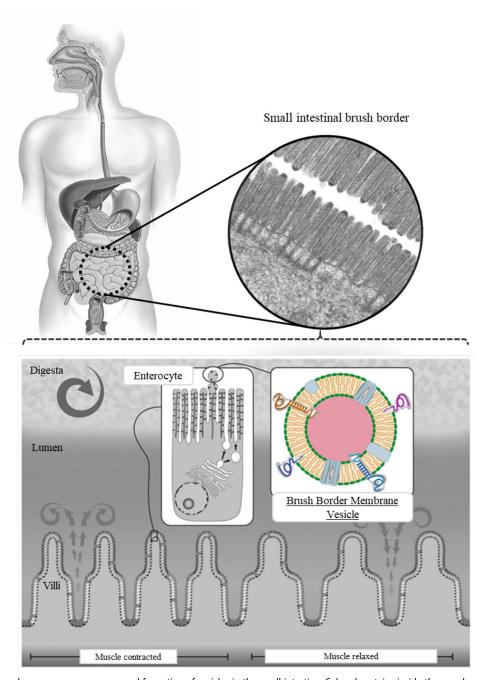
Brush border membrane enzymes presence and formation of vesicles in the small intestine. Colored proteins inside the membrane bilayer (green and yellow), represent the brush border enzymes with peptide (gold and pale blue) and glycosylphosphatidyl-inositol (dark blue and purple) anchors. BBMVs can be released into the adjacent periapical space, however, it is likely that the mucus layer overlying the ephitelia retards the egress of BBMVs from the periapical space into the lumen so that a significant amount of BBMVs would remain in close proximity to the intestinal mucosa.
